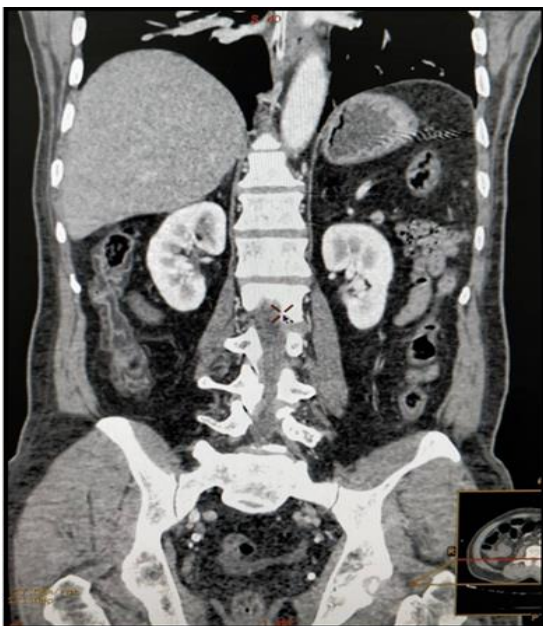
CT Coronal View showing collapsed large bowel
